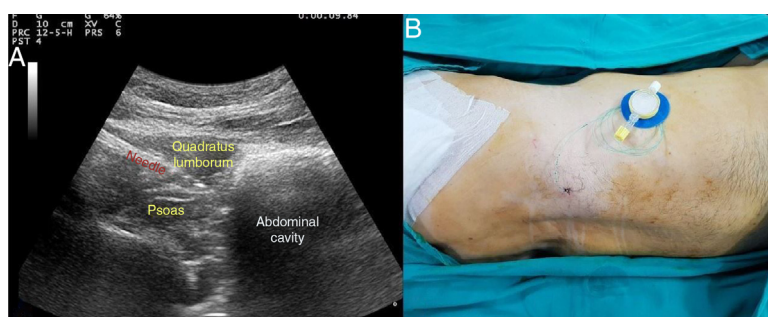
(A) Ultrasound image of quadratus lumborum block. (B) Quadratus lumborum block catheter position.
